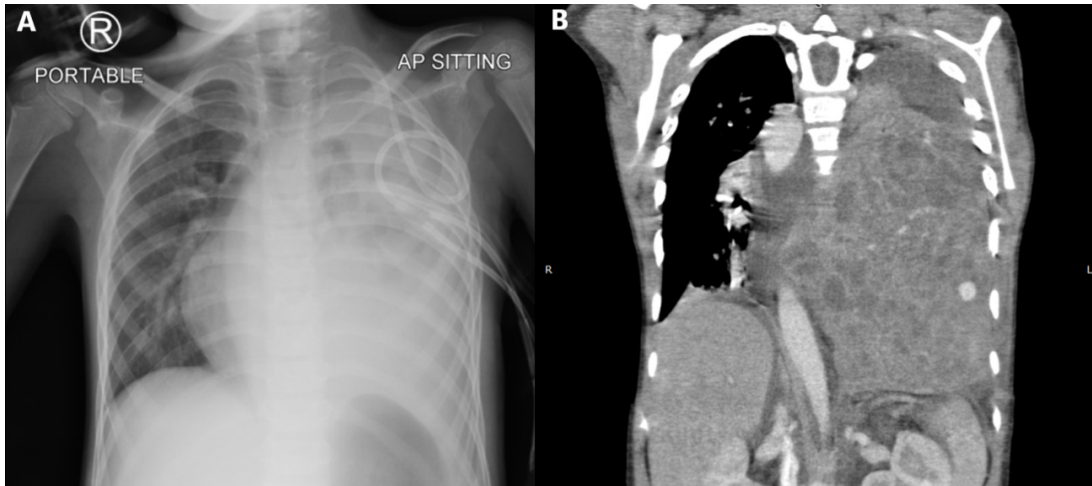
Chest radiograph (A) and contrast-enhanced Computed Tomography in coronal view (B). Large mass occupying left hemithorax causing homogeneous opacity of the left hemithorax on the radiograph (A). Huge heterogeneous mass was seen in the computed tomography (B) with evidence of multicystic component within.
